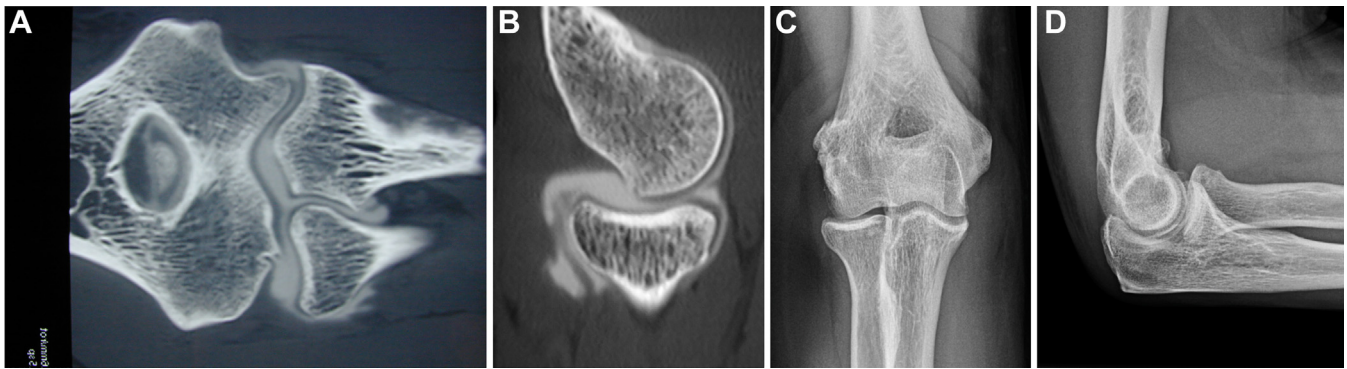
Preoperative CT scan (A and B) and radiographs at 15 years follow-up (C and D) in a professional sportsman. CT, computed tomography.
